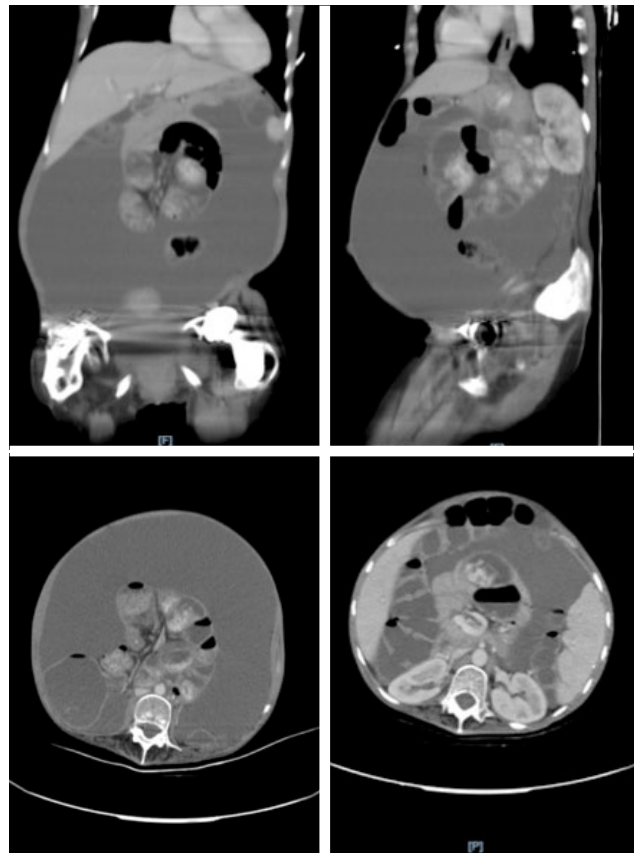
CT images of totally wrapped abdominal cocoon.
